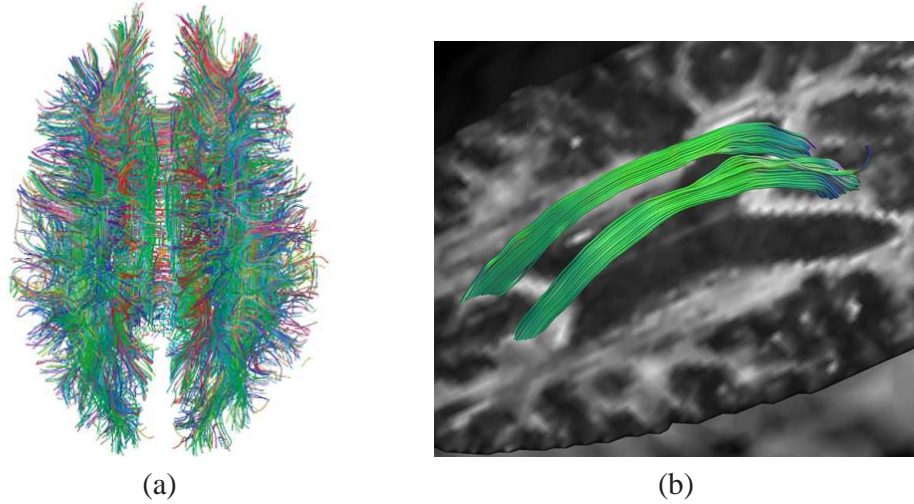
(a) Tractography: mapping fiber pathways (connections) in the human brain. The image is taken from [5]. (b) Tractography visualizations of diffusion MRI in region of interest overlaid on structural MRI: Superior segment of the bilateral cingulum fiber bundles. The image is adapted from [6].
